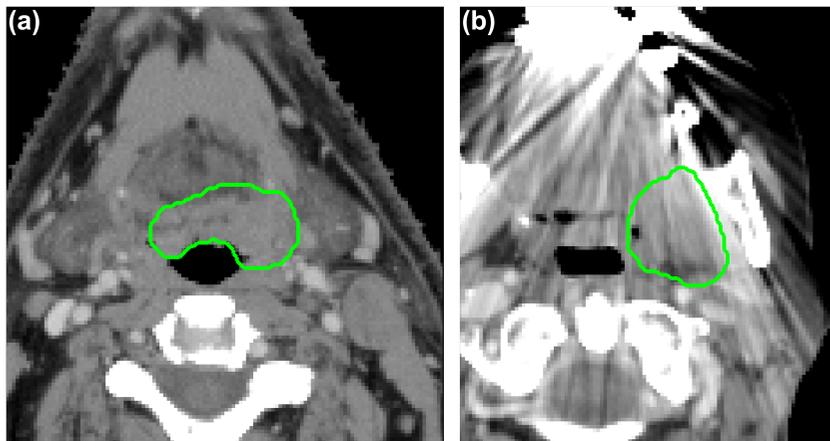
Representative images of OPSCC patients from the validation cohort, without (a) and with (b) visible CT artifacts. The GTV delineation is shown in green.
